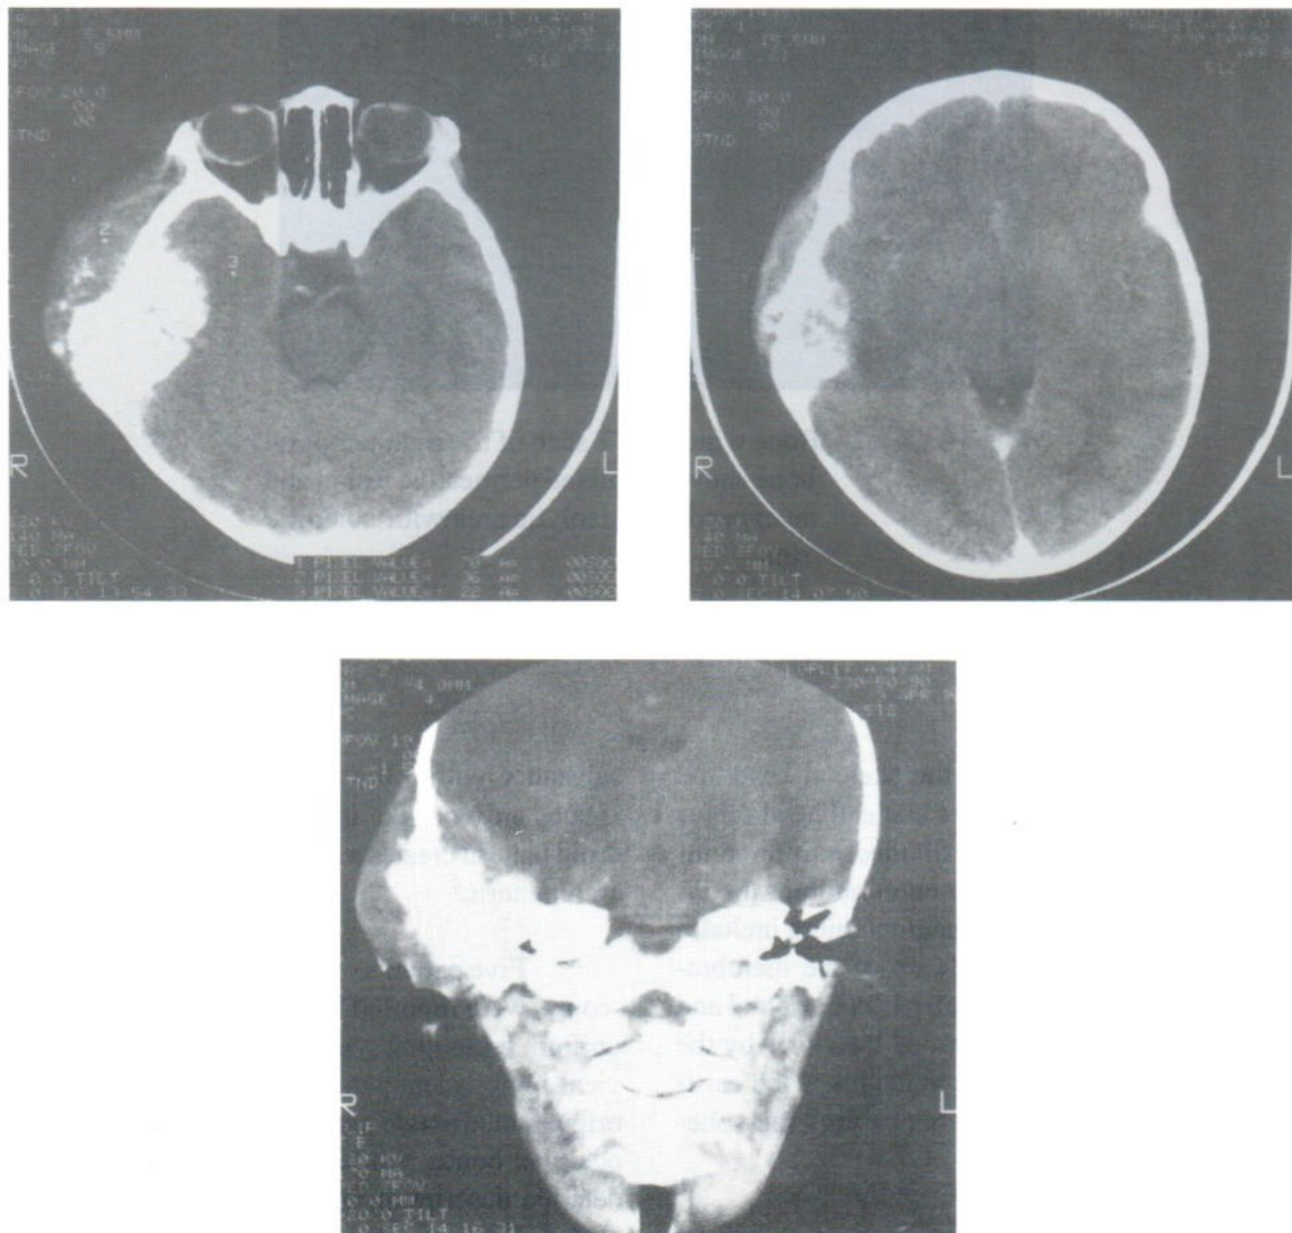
Case 2. Most of the intracranial part of the mass showed dense calcification by CT scan.
